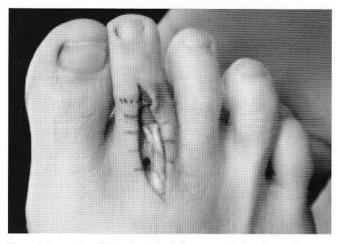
Inspection of the arthrodesis site intra-operatively, prior to closure, to ensure proper apposition, seating and locking. Intraoperative radiographic confirmation is strongly recommended.
